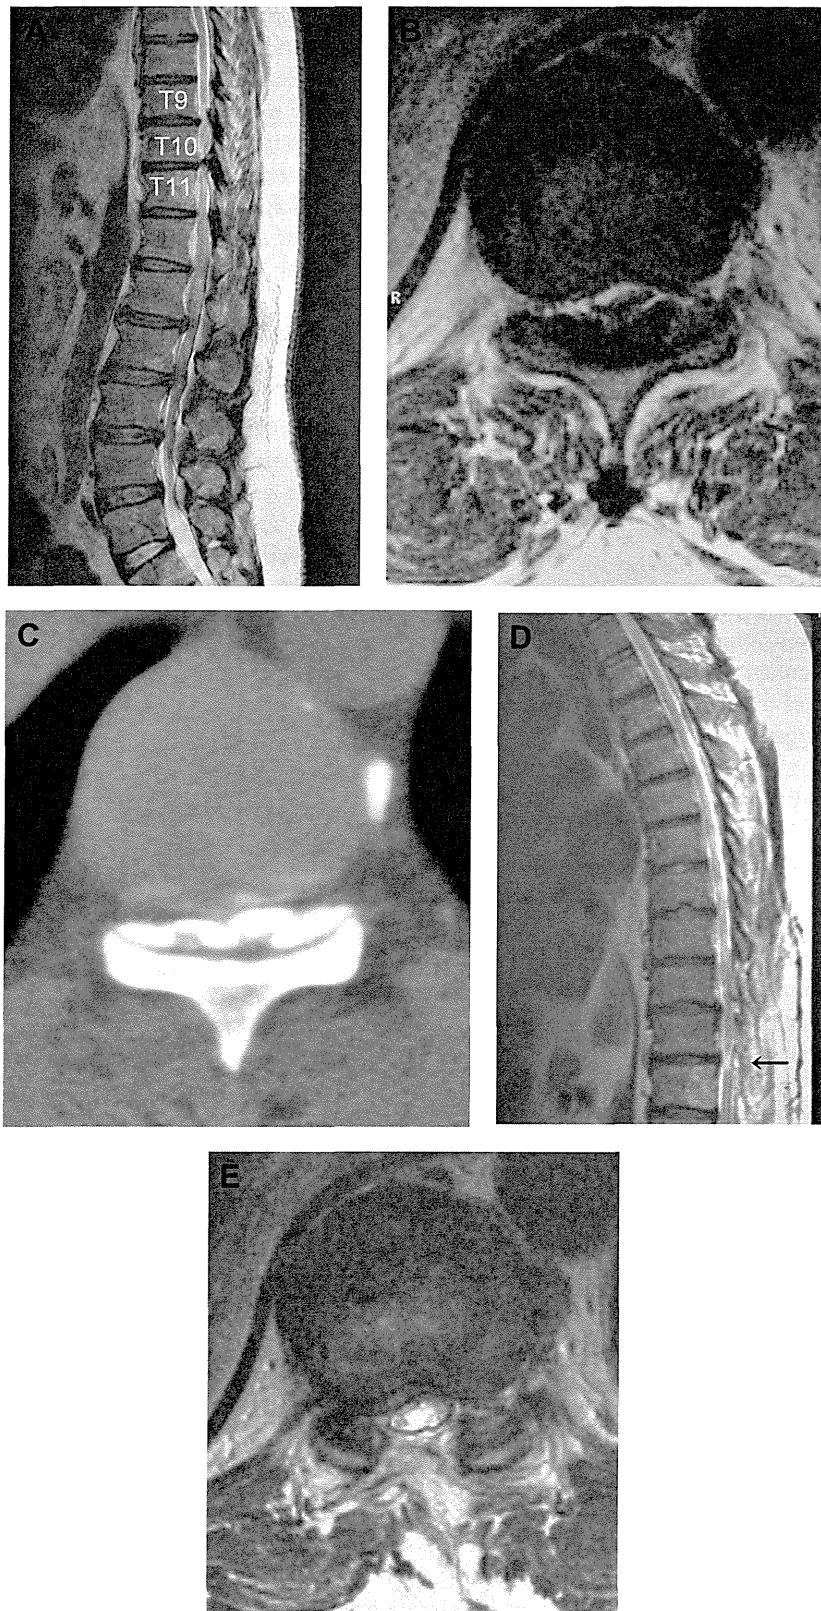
Radiographic findings in Patient 21. (A) Presurgical sagittal T2-weighted magnetic resonance imaging (MRI) view showing spinal cord compression at T9–T10 and T10–T11 levels. (B) Presurgical axial T2-weighted MRI showing spinal cord compression at T10–T11 and intramedullary signal change. (C) Computed tomography myelogram at T10–T11 level. (D) Postsurgical sagittal T2-weighted MRI showing decompression of the spinal cord at T9–T10 and T10–T11 (arrow). (E) Postsurgical axial T2-weighted MRI view revealing decompression of the spinal cord at T10–T11, but remaining presence of intramedullary signal change.
